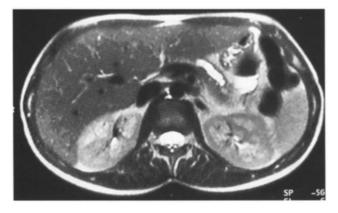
MRI T2WI dilated pancreatic duct.
